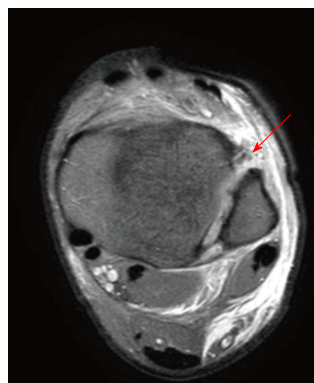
Axial plane of magnetic resonance imaging showing a full thickness tear of the anterior part of the syndesmosis (red arrow).
